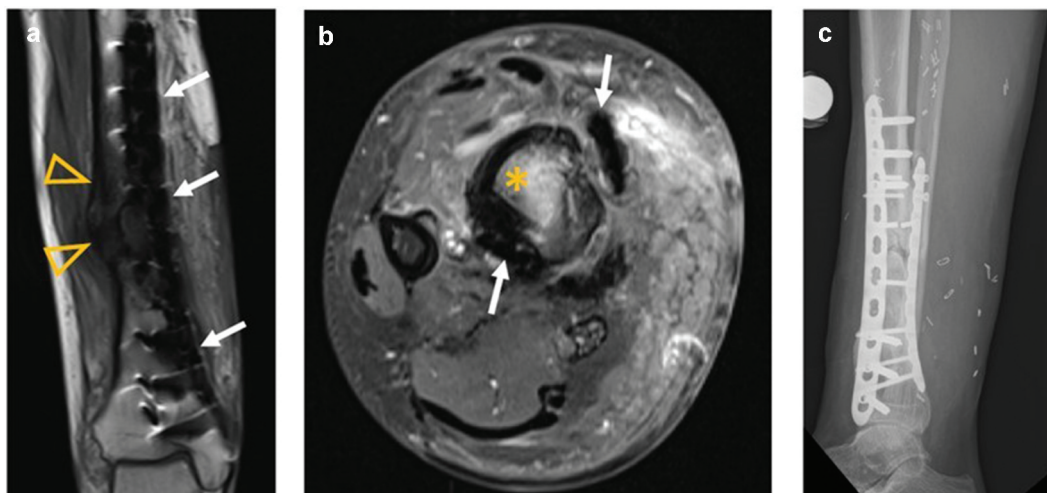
Clinical case of 38-year-old male patient with non-union of a tibial fracture with chronic osteomyelitis with hypointense signal of (a) the bone marrow (arrowheads) in the T1-weighted coronal MR image and (b) contrast enhancement of the bone marrow (asterisk) on the transverse fat-saturated T1-weighted MR image after intravenous gadolinium administration. Both mr-sequences have been acquired with increased readout bandwidth to reduce the metal artifacts of the osteosynthesis (arrows). Note that on (c) the lateral radiograph several screws are fractured proximal to the non-union.
